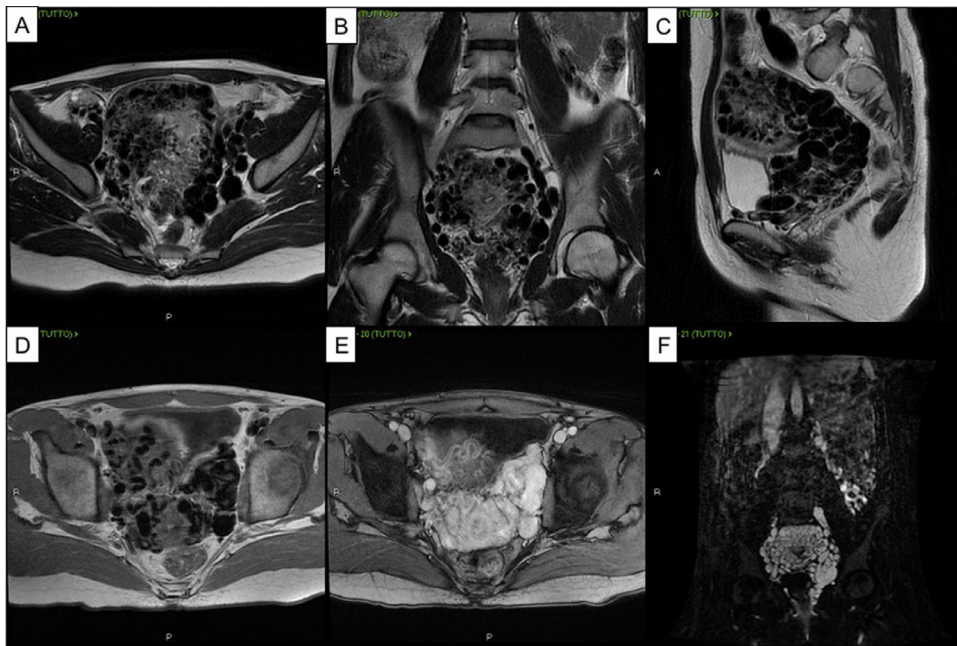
A 36-years-old female with menometrorrhagia and history of multiple spontaneous miscarriages. Preprocedural MRI showing a complex congenital AVM with uterine and extrauterine feeders. The vessel proliferation has completely subverted the uterine structure. T2-weighted sequence in axial (A), coronal (B) and sagittal (C) planes; T1-weighted sequence in axial plane (D); contrast-enhanced T1-weighted sequence in axial plane(E); TRICKS sub sequence (F).
